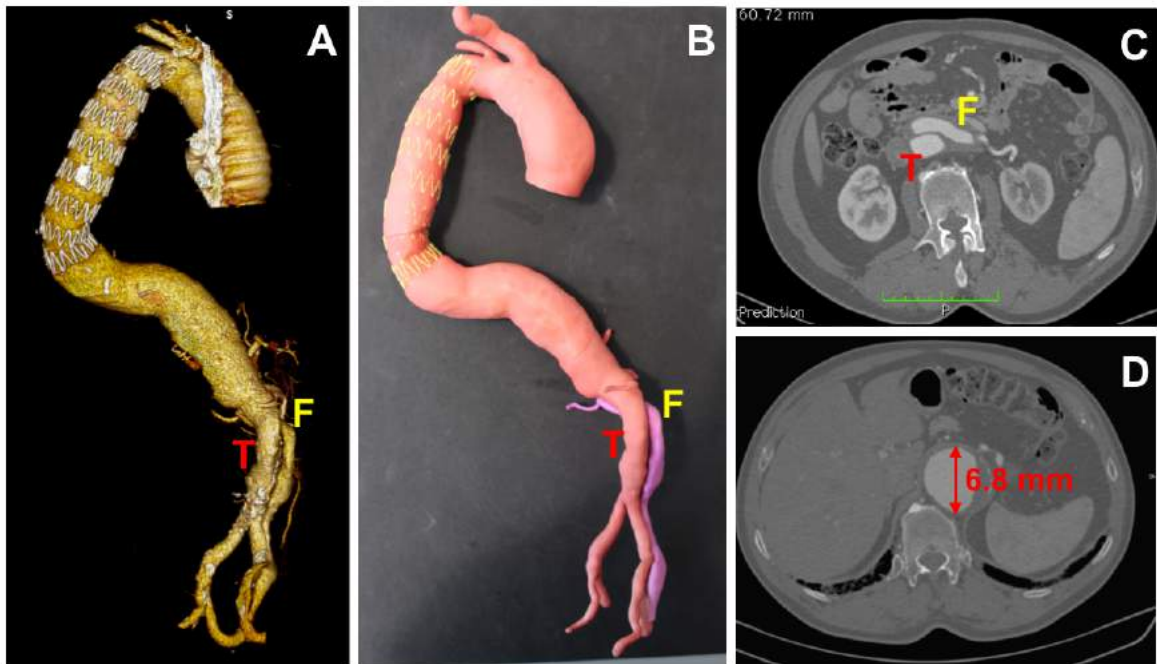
(A) 3D rendering and (B) 3D printed model show a chronic dissected TAAA. True (T) and false (F) lumen are highlighted both in the 3D models (A-B) and in the CT (C). (D) Maximum diameter reached 6 years after the first TEVAR intervention.
